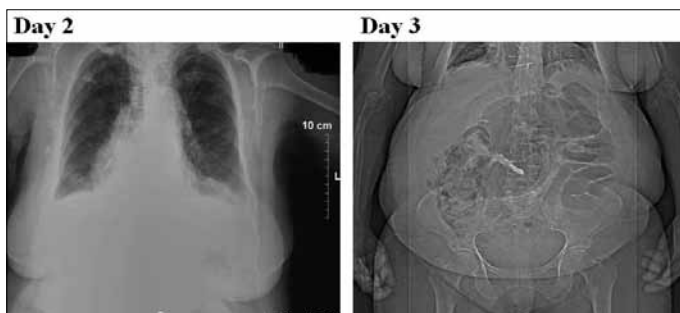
Sequential post-bypass abdominal X-ray on day 2 and 3: No evidence of intestinal perforation. However, certain radiological findings of intestinal enlargement and abdominal distention are seen
